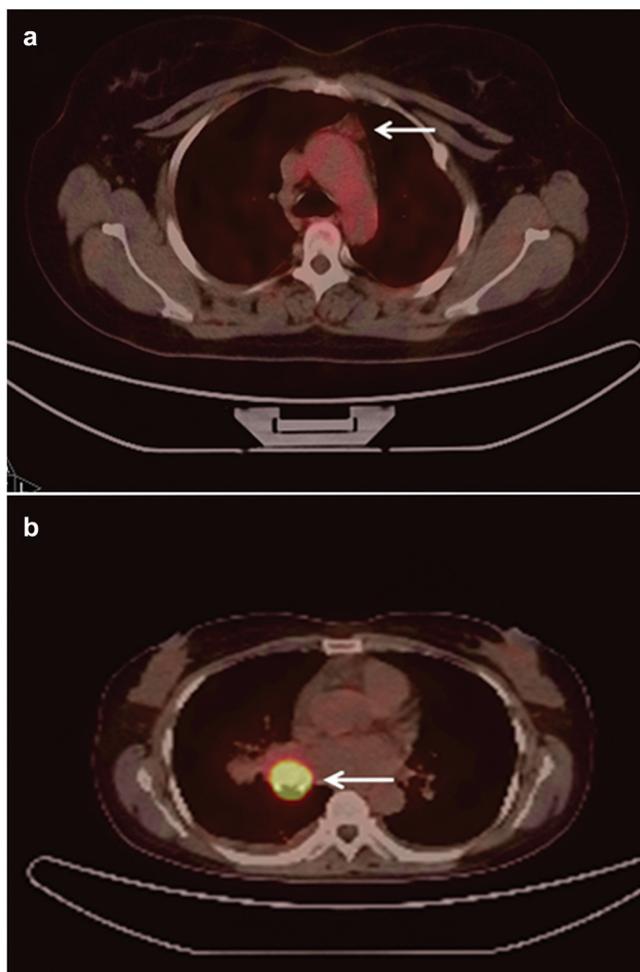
^{68}Ga DOTATOC PET-CT-scans (a) showing no uptake of radiotracer in thymic carcinoid (arrow) and (b) showing intense uptake of the radiotracer in bronchial carcinoid (arrow) for comparison. ^{68}Ga DOTATOC PET-CT, ^{68}Ga -Galium-1,4,7,10-tetraazacyclododecane-NI, NII, NIII, NIIII-tetra acetic acid-(D) – Phe1-Tyr3-octreotide positron emission tomography.
